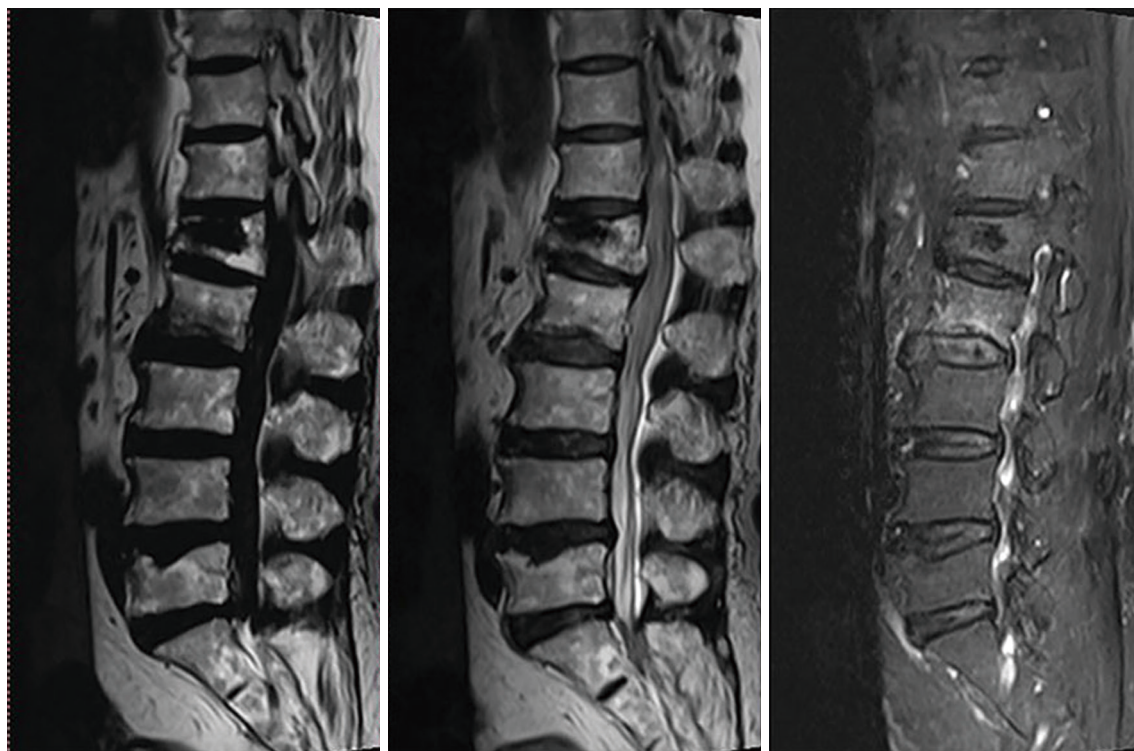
MRI findings: the cross-section of L1 vertebral body was deformed and its height was reduced. There were low signal intensity of T1 and T2 in L2 vertebral body and high signal intensity of FST2 in L2 vertebral body, L4–5 lumbar intervertebral disc herniation, dural sac compression, no significant changes in spinal cord signal.
